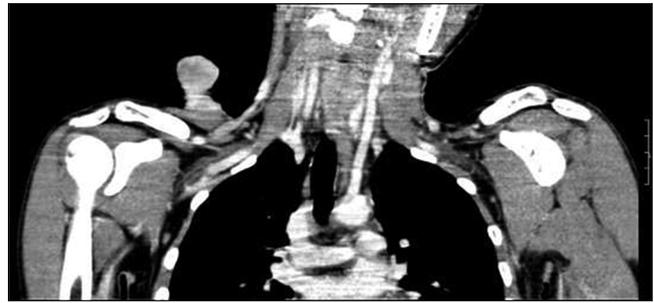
Computed tomography scan of local part was done which revealed multiple nodular soft tissue growth over the right supraclavicular region, arteriogram showed arterial supply by the transverse cervical branch of right subclavian artery, venous drainage by the external jugular vein, no evidence of erosion of ribs or clavicle and no abnormal soft tissue mass seen in lungs
